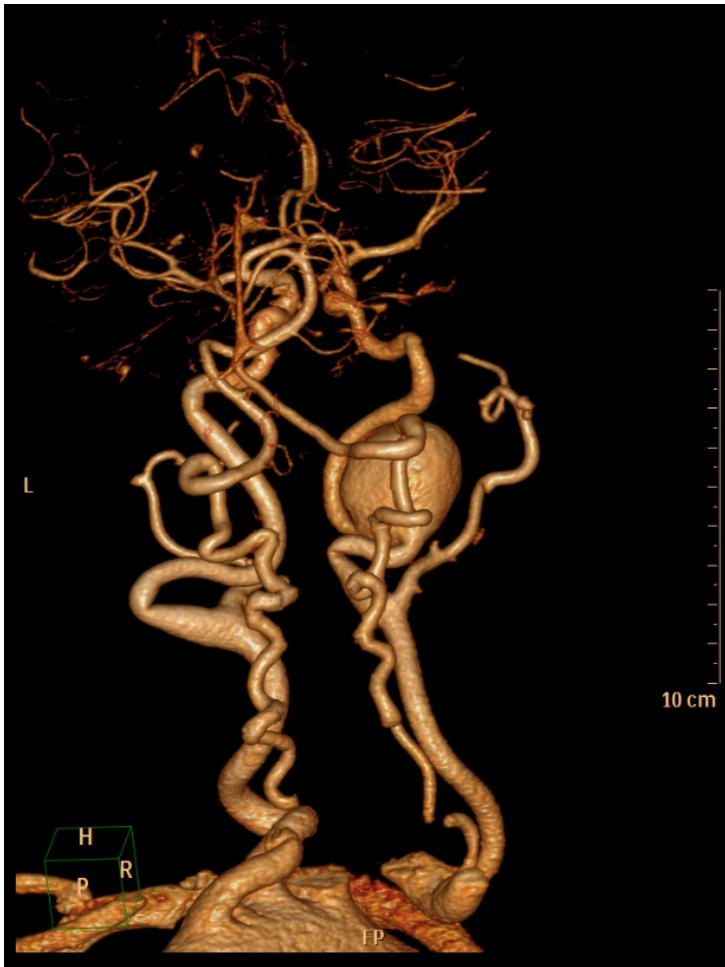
3D CTA of a saccular aneurysm of the ICA.
